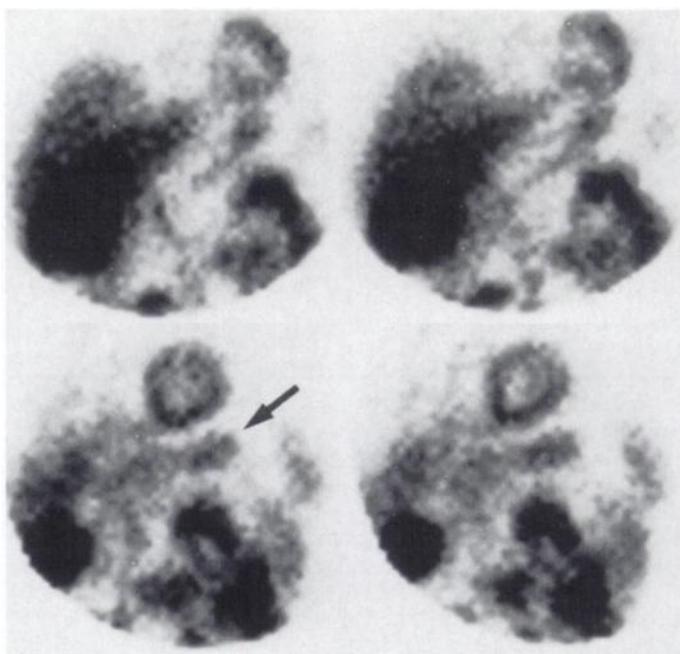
Moderately intense enterogastric bile reflux in a 53-yr-old man with coronary artery disease previously treated by angioplasty. Four images from a dipyridamole pharmacologic stress ^{99m}Tc -sestamibi SPECT study show moderately intense activity in the stomach (arrow) equal intensity to the myocardial uptake.
